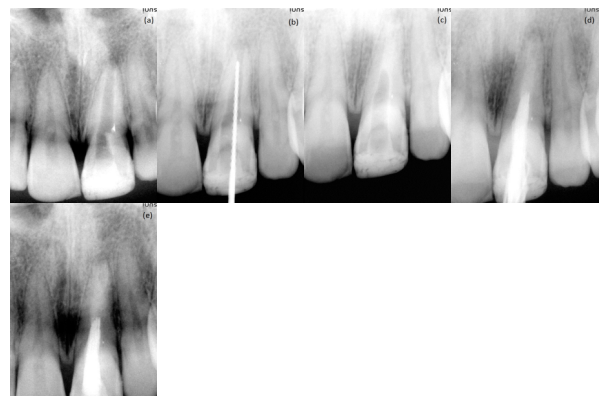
Case 1. (a) Preoperative radiograph showing 21 open apex and periapical radiolucency (b) working length (c) confirming the placement of Biodentine apical barrier (d) back filling with gutta percha using roll cone technique (e) 3 month follow up showing resolution of periapical radiolucency.
